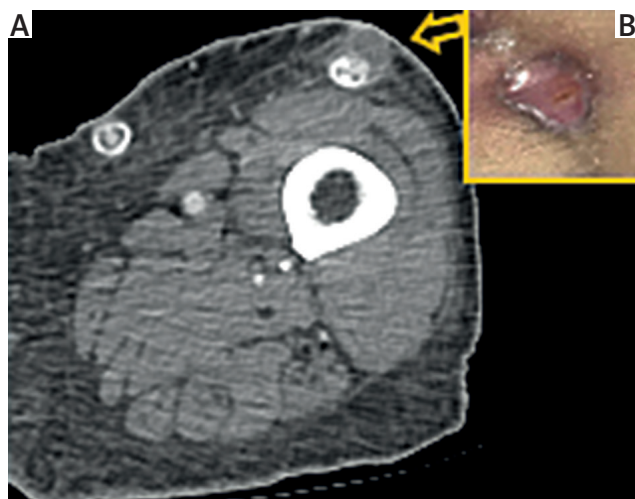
A – Pus accumulation was detected in the CTA around the locally destroyed graft from multiple cancellations. B – The locally infected graft
